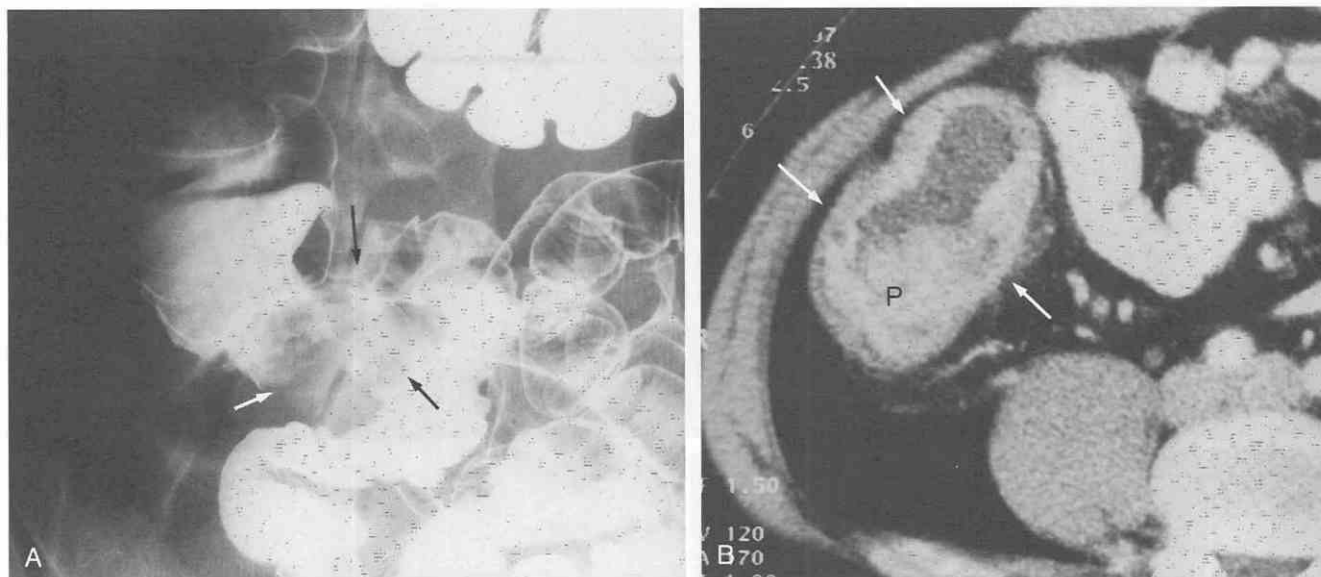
Behçet's syndrome. A, Double-contrast barium enema shows multiple, discrete ulcers with thickened mucosal folds (arrows) at the terminal ileum. B, CT scan shows both bowel wall thickening (arrows) and a polypoid masslike lesion (P) at the ileocecal region. (From Ha HK, Lee SH, Rha SE, et al: Radiologic features of vasculitis involving the gastrointestinal tract. *Radiographics* 20:779-794, 2000.)
